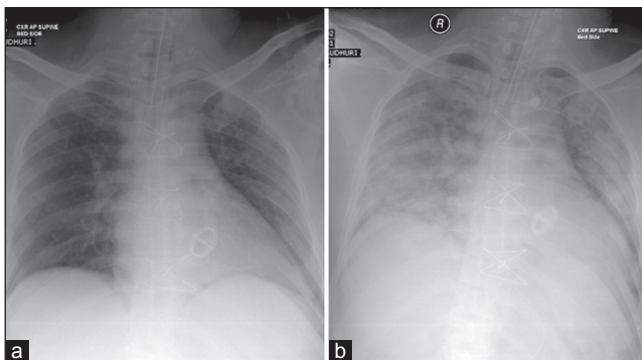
Chest X-ray on (a) admission and (b) 2nd day in critical care unit (CCU; bilateral infiltrations); prosthetic mitral valve (arrow)
